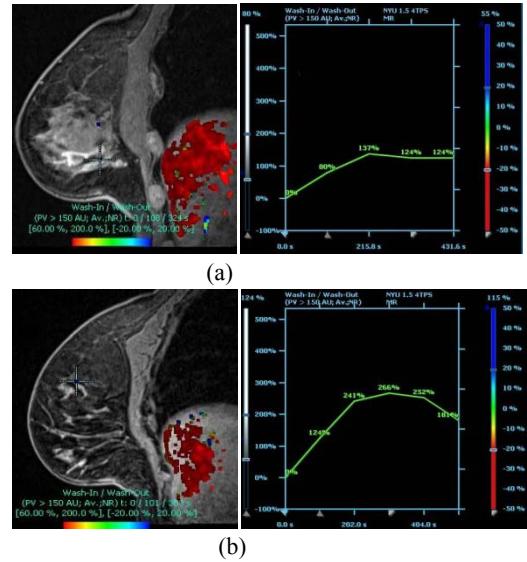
DCE MRI with DynaCAD kinetic parameters demonstrating time to peak and percent peak enhancement. (a) Benign 6mm mass (b) Malignant 6mm mass
